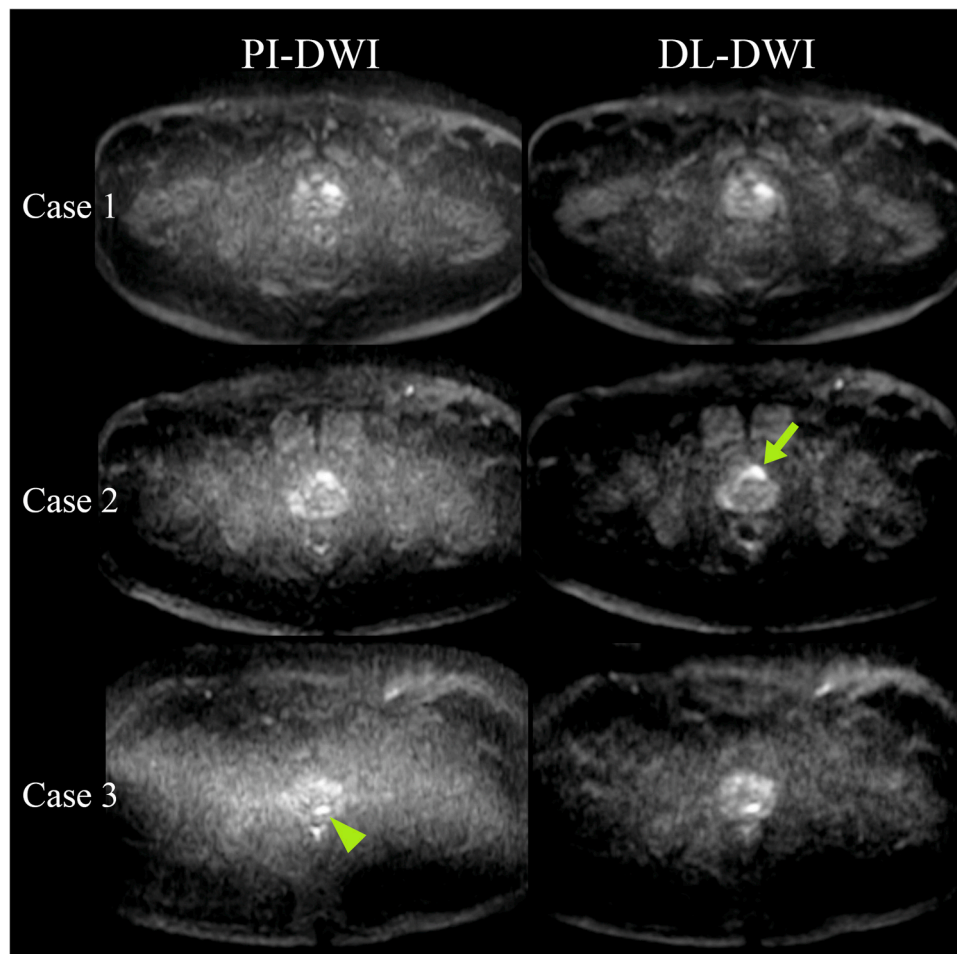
Representative results of PI-DWI and DL-DWI. The findings of three representative patients with prostate cancer (PCa) examined with both PI- and DL-DWI are presented (Patient 1: *upper row*, Patient 2: *middle row*, and Patient 3: *lower row*). In Patient 1, both PI-DWI and DL-DWI were able to detect PCa, but in DL-DWI only, the anatomical structures in the background were clear due to the marked decrease of the overall noise. In Patient 2, PI-DWI showed moderate noise in the central area on the image, and the outline of the prostate was partially unclear. In this patient's DL-DWI, the image noise observed in the central area was remarkably decreased, and the outline of both the prostate and the PCa (*arrow*) was visible. In Patient 3, PI-DWI presented severe noise in the central area, making the prostate outline barely visible. The lesion, identified as PCa (*arrowhead*), was discernible, though there was considerable noise not associated with the lesion. In the patient's DL-DWI, both the prostate outline and the lesion were clearly identified with an effective decrease of the noise.
